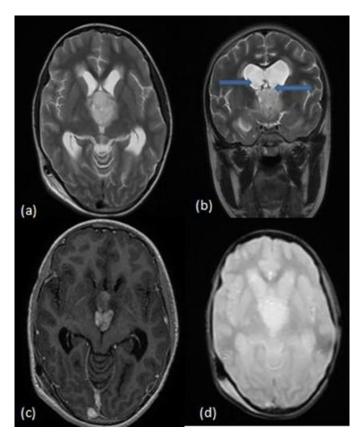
T2W axial and T2W coronal MR images show T2 hyperintense lesion in third ventricle (arrow) causing compression of bilateral foramen of Monro with dilatation of bilateral lateral ventricles (a-b); post-contrast T1W axial MR image shows the lesion showing heterogenous enhancement (c); GRE axial MR image shows no blooming in the lesion (d).
